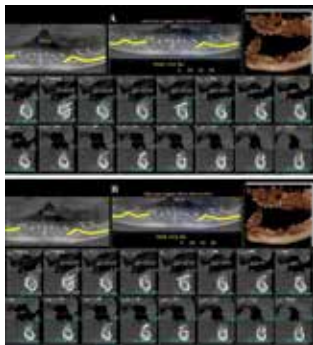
Cone beam computed tomography (CBCT) image of the mandible after six months (left & right).
